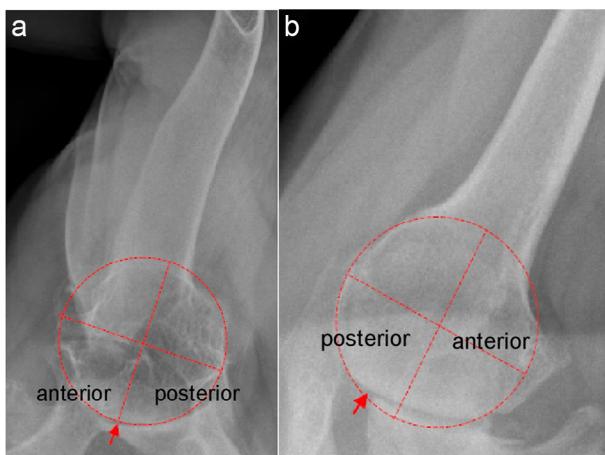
Humeral head apex in the transverse plane on axial view radiograph. (A) Example for centered apex (arrow). Here, the apex is in line with the center of rotation within the area of the best-fitting circle of the humeral head. (B) Example for decentered humeral head apex in the transverse plane. Here, the apex (arrow) is posteriorly decentered in relation to the center of rotation and the best-fitting circle of the humeral head.
